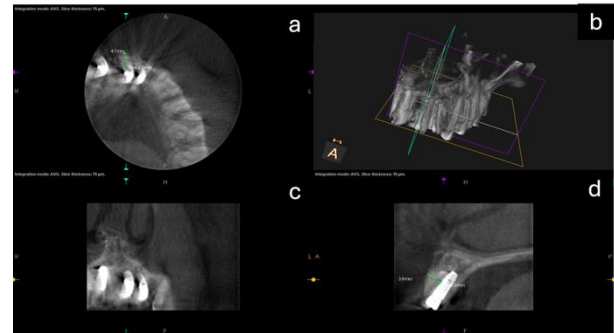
Three-month postoperative CBCT of the AutoBT-augmented ridge. (a) Axial slice demonstrating preservation of the bucco-palatal ridge width (green calibre). (b) 3-D volume-rendered model with the re-oriented slicing plane super-imposed. (c) Sagittal slice showing a continuous labial cortical outline and early trabecular infill within the grafted socket. (d) Coronal slice centred on the former tooth-21 site, showing good ridge width and homogeneous radiopacity indistinguishable from adjacent native bone.
